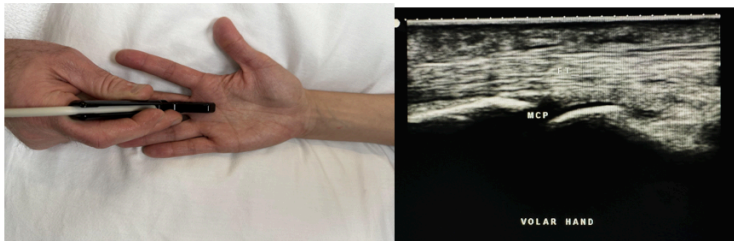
Side-by-side pictures of the transducer position and sagittal volar hand imaging of the metacarpal phalangeal joint (MCP) and the flexor tendon (FT). The abbreviations given here and labeled on the ultrasound image represent the corresponding structures.
